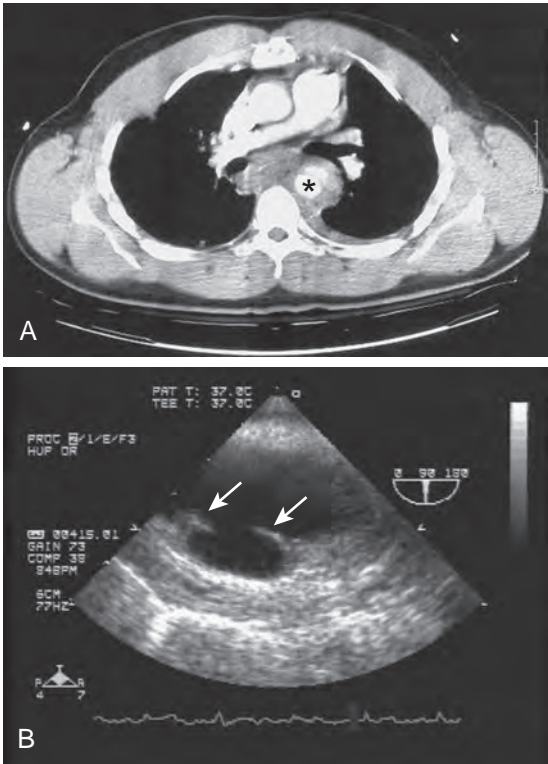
Computed tomographic angiogram of the chest (A) in a trauma patient who presented with a widened mediastinum on the chest roentgenogram demonstrating traumatic intimal disruption of the aorta in the region of the aortic isthmus (asterisk). Perivascular hematoma and extravasation of contrast agent into the mediastinum and left pleural cavity indicated a rupture of the descending aorta. Intraoperative transesophageal echocardiographic (TEE) long-axis image of the proximal descending thoracic aorta (B) demonstrated a thick mural flap (arrows) and surrounding hematoma at the site of the intimal disruption.
